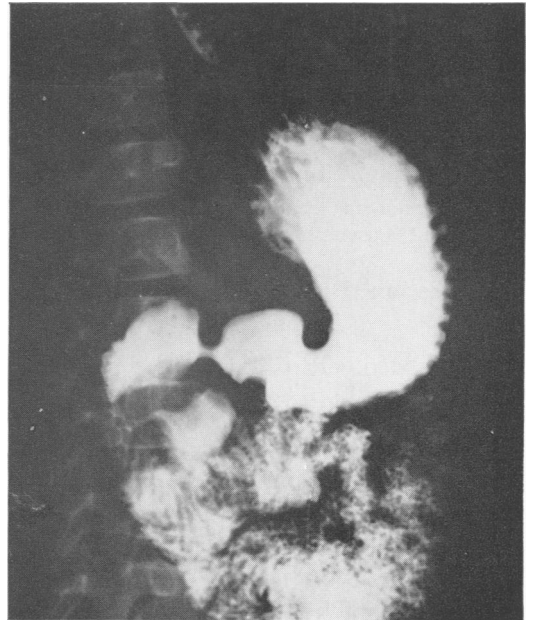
Postoperative roentgenogram showing duplication of duodenum. Note that following enteroenterostomy, the duodenal duplication fills with barium from the jejunum. There is no connection with duodenal bulb or biliary system.
